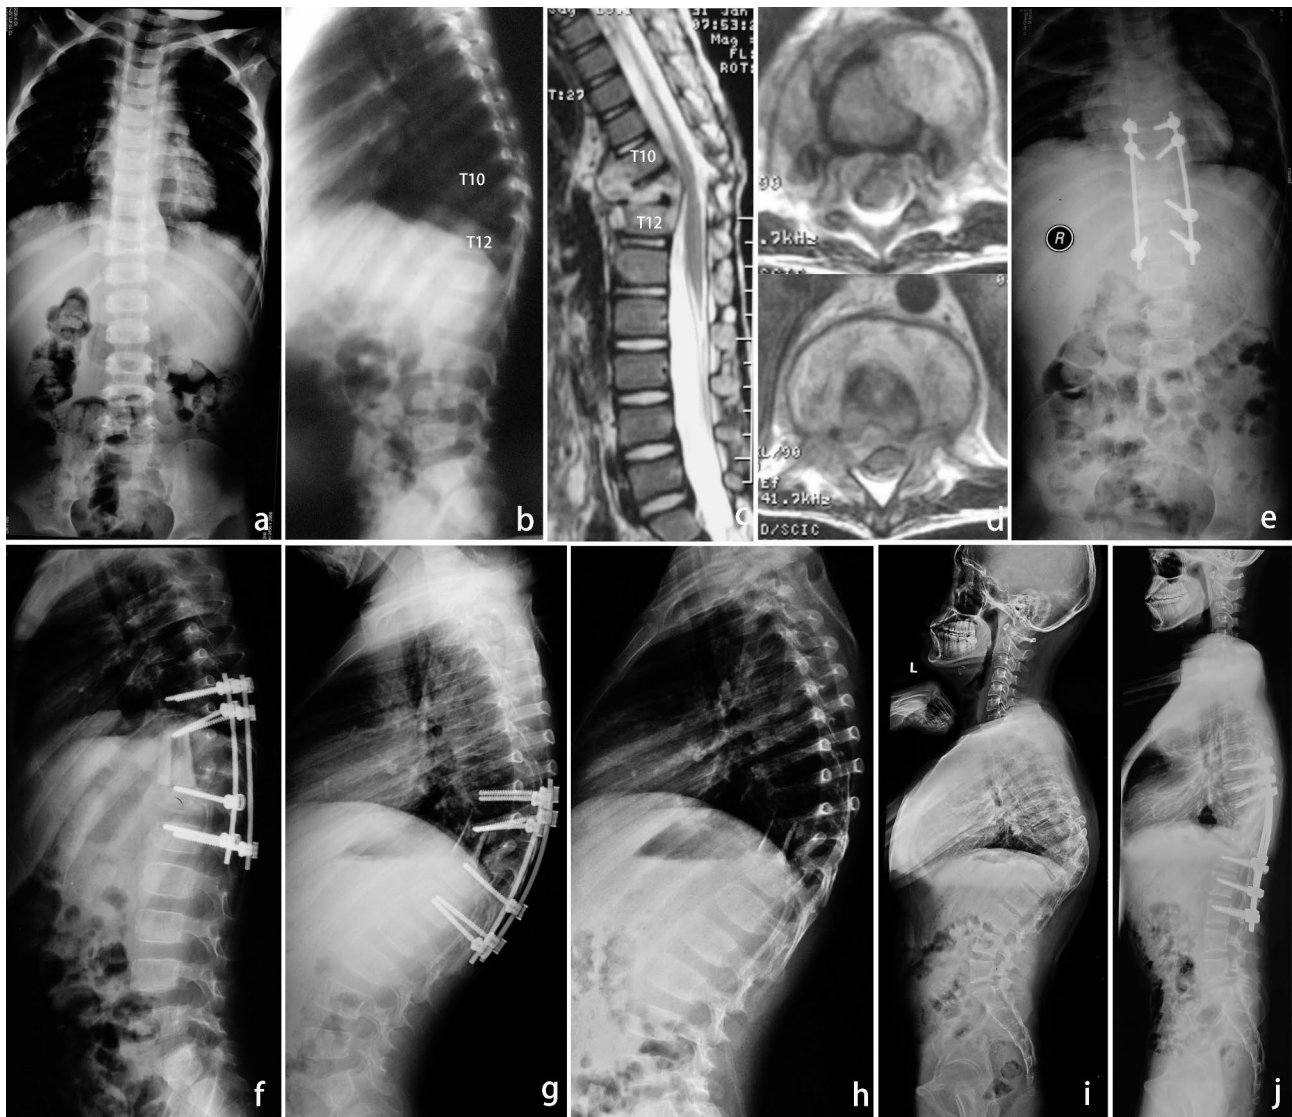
(a-d) Preoperative images of a 6-year-old boy showing severe destruction of the T11 vertebral body with kyphosis; (e, f) A posterior-anterior surgical approach was performed; (g) Three-month postoperative radiographs showing strut bone displacement with loss of correction; (h) Although the TB was cured two years post-surgery, the patient requested internal fixation removal due to back discomfort; and (i, j) Significant kyphosis progression was observed at 163 months postoperatively and posterior osteotomy and corrective surgery was performed
